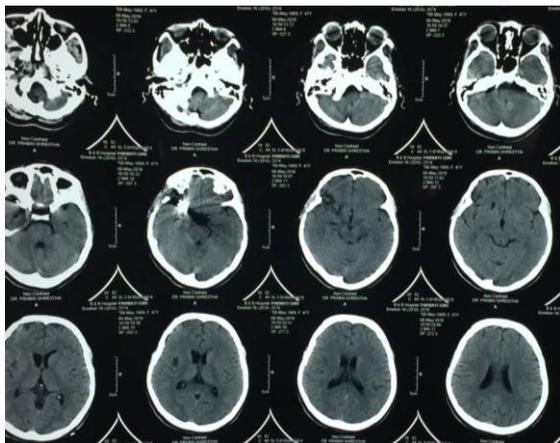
Post-operative CT scan showing clip in the right sylvian region
